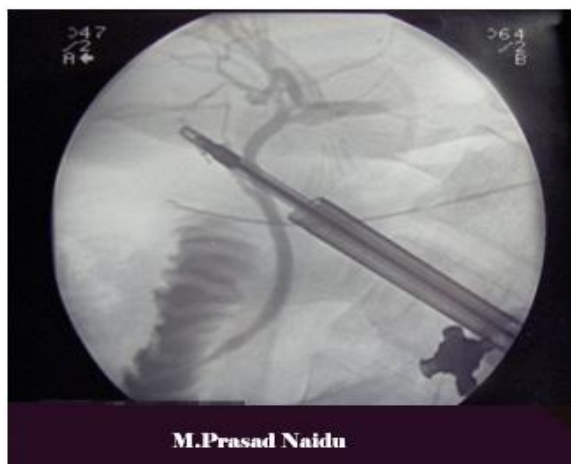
4 X-Ray during laparoscopic cholecystectomy.
